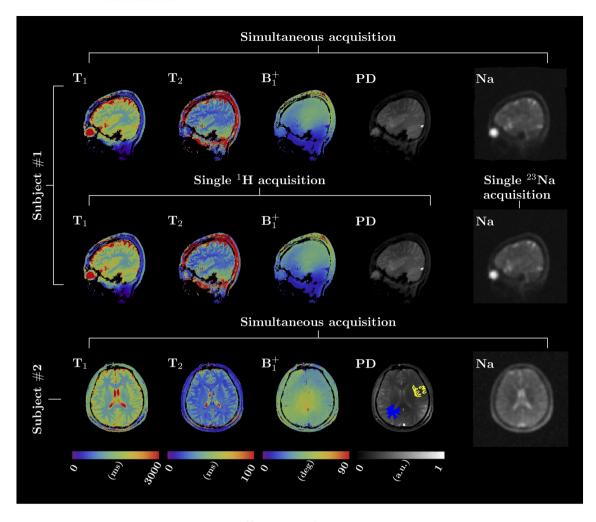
Proof of concept for simultaneously acquired ²³Na MRI and ¹H MR fingerprinting used to generate T_1 , T_2 , B_1^+ and PD maps of the human brain at 7 T on two healthy subjects. The sagittal images extracted from the simultaneous acquisition and the single-nucleus scans are shown for Subject 1. Figure reproduced with permission from Reference⁷⁰
